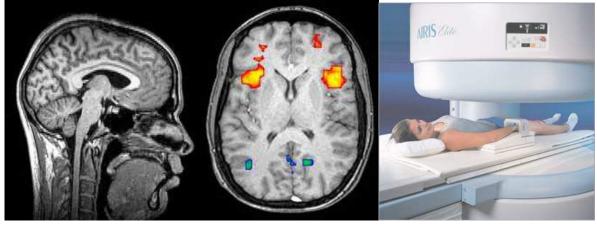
Magnetic Resonance Imaging (Sagittal MRI)
